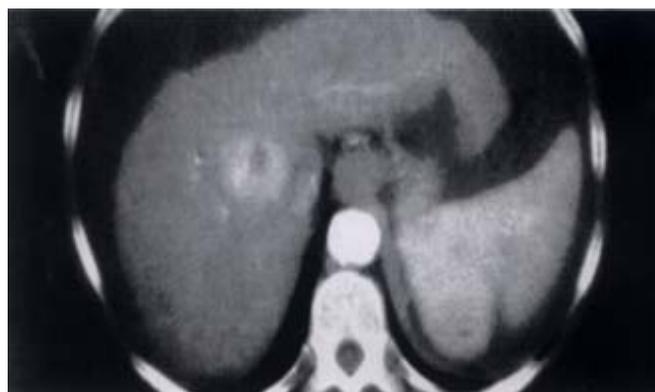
CT Scan showing HCC in cirrhotic liver with ascites and splenomegaly.
